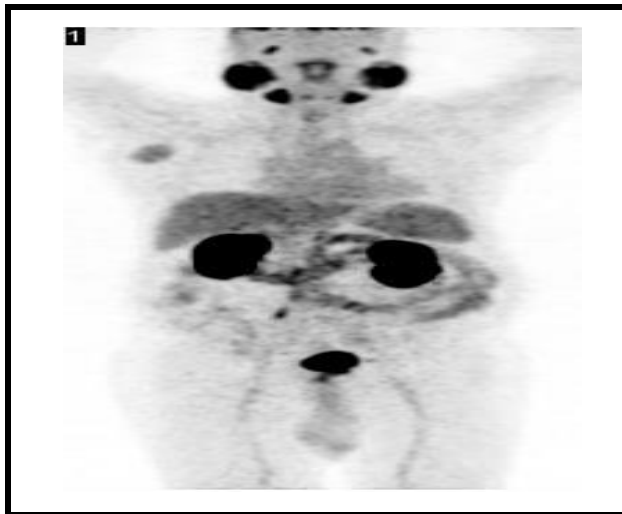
A): ^{68}Ga -PSMA PET/CT shows prostatic uptake below the bladder as well as a focus of uptake in the right axilla. The PSA level at the time of imaging was 39ng/ml.
